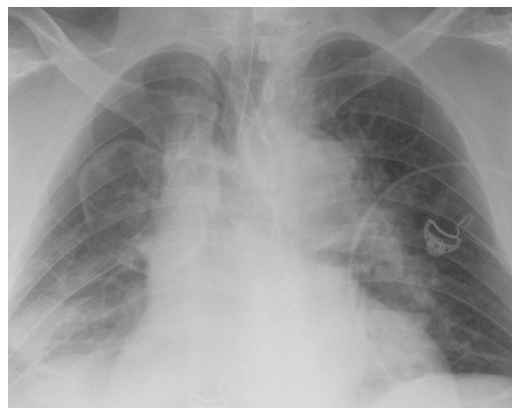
Overinflated endotracheal tube balloon. AP chest radiograph shows an endotracheal tube cuff that is inflated sufficiently to cause widening of the trachea. The cuff should fill, but not expand, the tracheal lumen.
